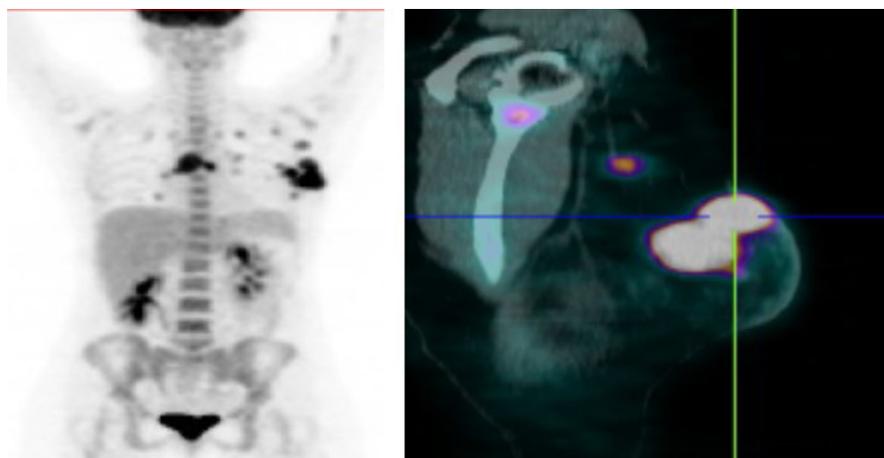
PET-CT after second line palliative chemotherapy
